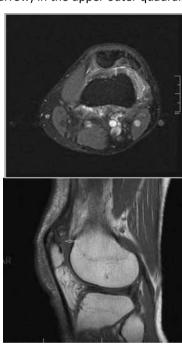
a) Axial fat-suppressed proton density-weighted, b) Sagittal T1-weighted images shows the cartilage overlying the patella and accessory fragments and confirms the presence of cartilage signal (arrow) across the synchondrosis
